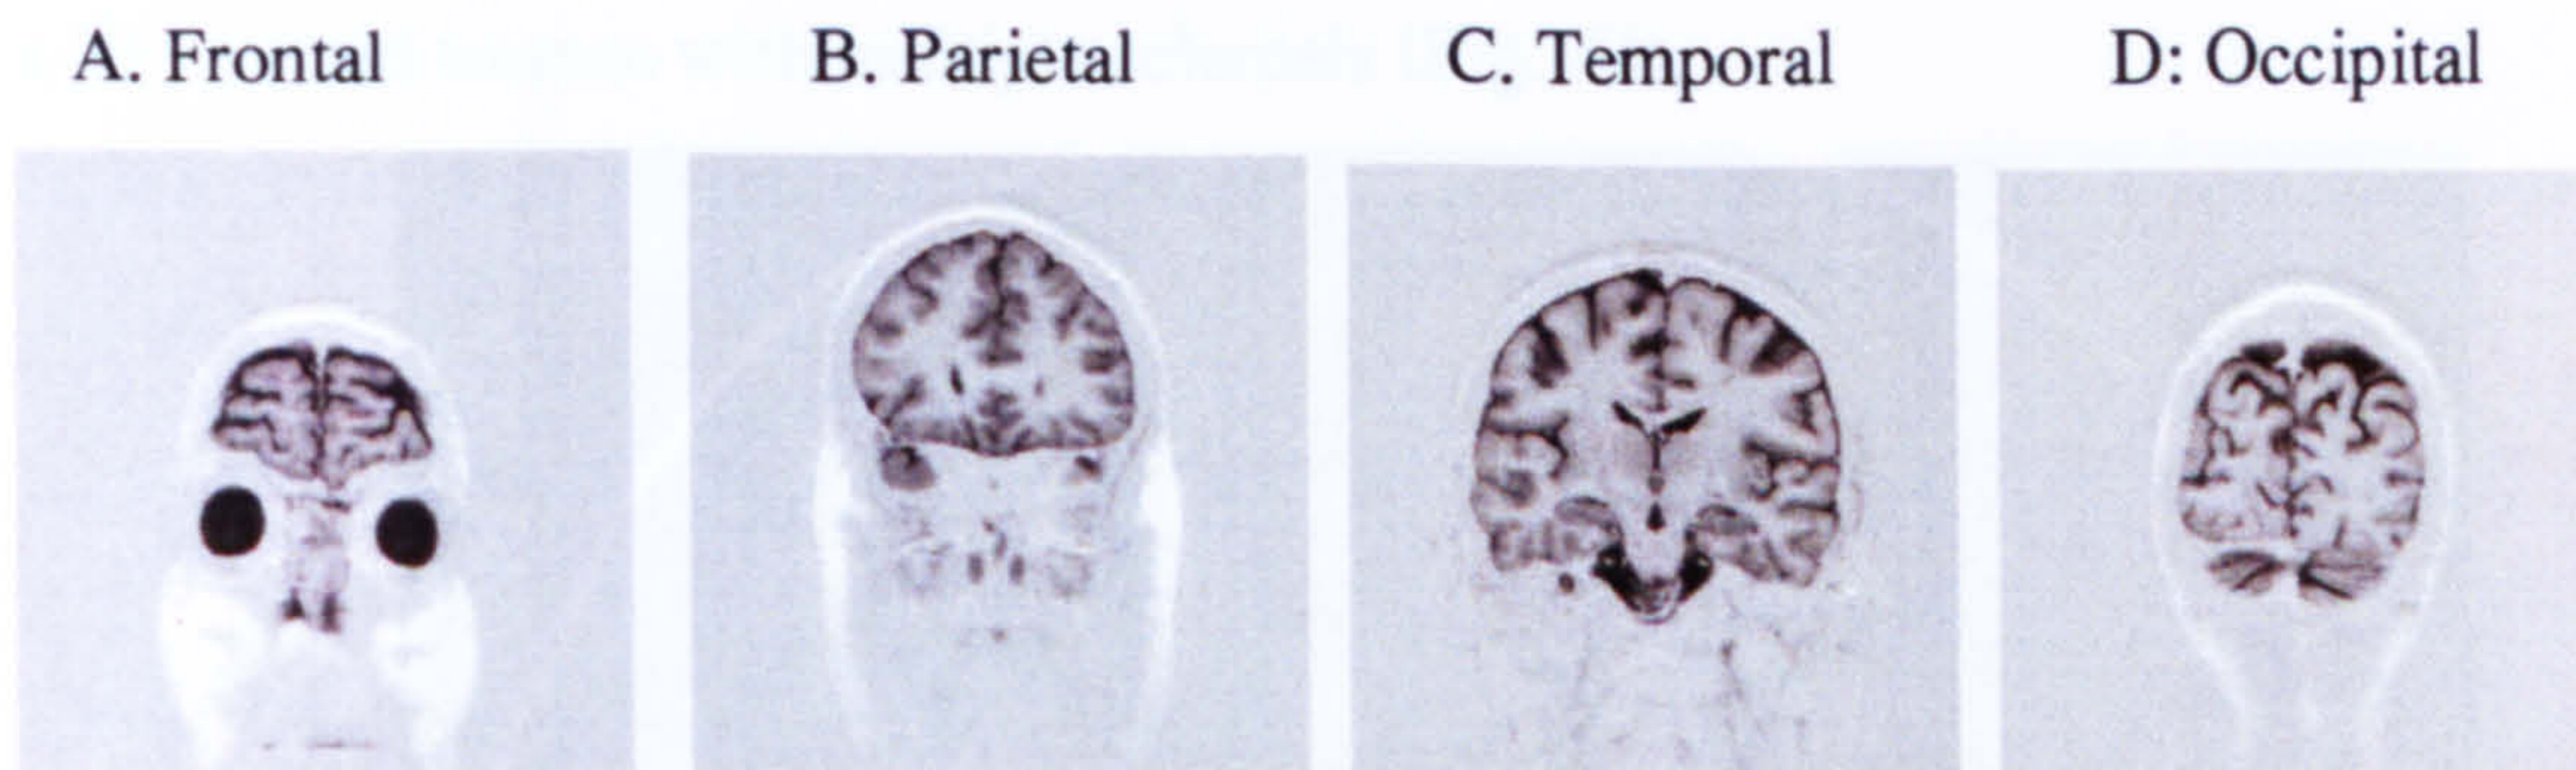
Coronal FLAIR sequence perpendicular to the corpus callosum
